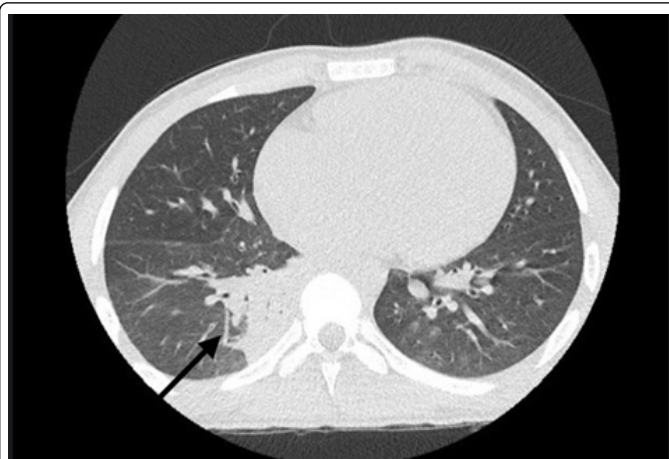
CT scan on day 6 of hospitalization: Non-calcified subpleural nodule in the right lower lung lobe, 6 mm, suggestive of a small lymph node.
